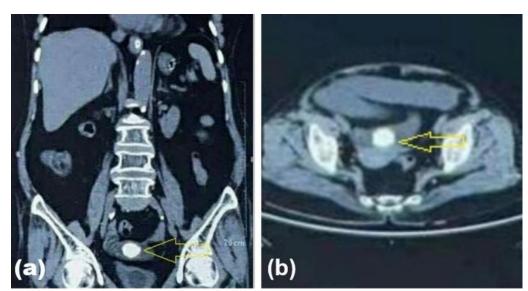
(a) Coronal contrast-enhanced CT of the abdomen and pelvis showing a large gallstone (yellow arrow) impacted in the distal ileum, causing small bowel obstruction consistent with gallstone ileus. (b) Axial CT abdomen with contrast showing impacted gallstone (3 cm) in the terminal ileum
